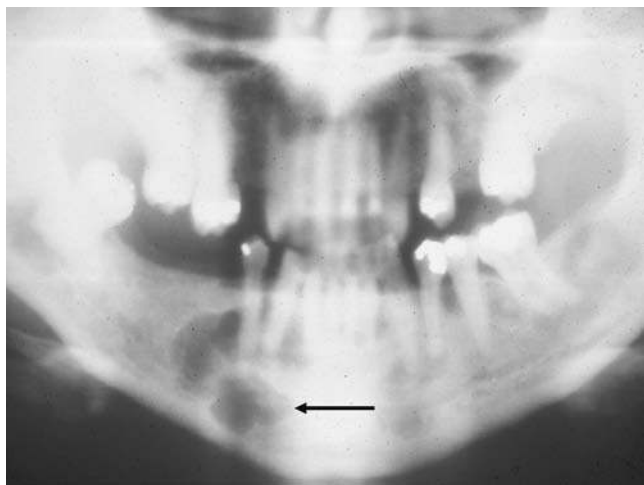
Plain film highlighting an ossifying fibroma. Note the well circumscribed nature of the lesion (*arrow*).
